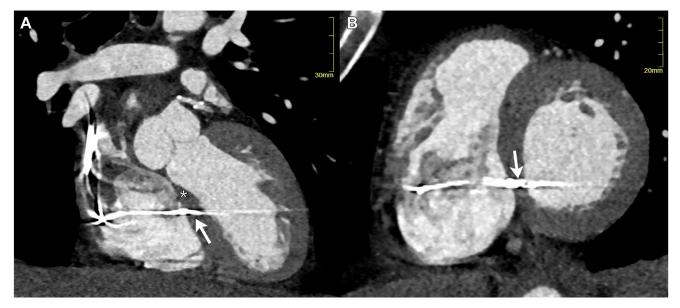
Left anterior oblique cranial (A) and short-axis views (B) on cardiac computed tomography showing a lead tip position (*arrow*) 12 mm inferiorly from the insertion point of the septal leaflet of the tricuspid valve (*asterisk*) and in the posterior third of the interventricular septum.
